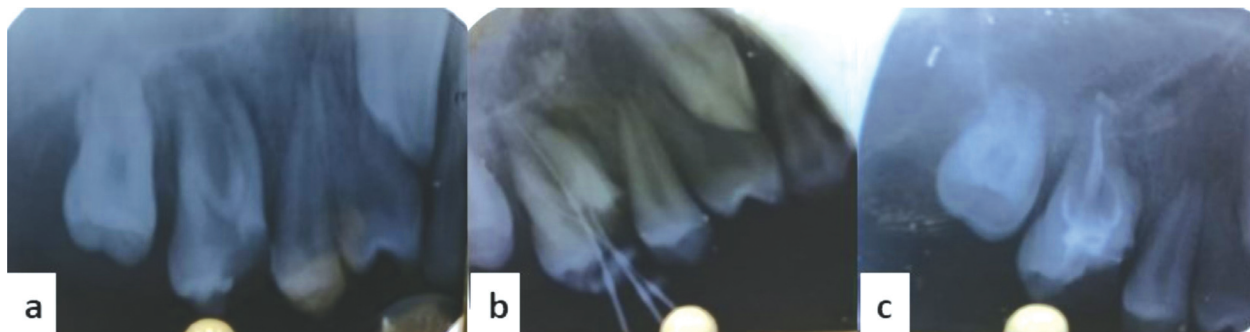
Preoperative intraoral periapical radiograph of left maxillary first molar; 2b. Canal length determination in intraoral periapical radiograph of left maxillary first molar; 2c. Intraoral periapical radiograph showing obturation of left maxillary first molar.
